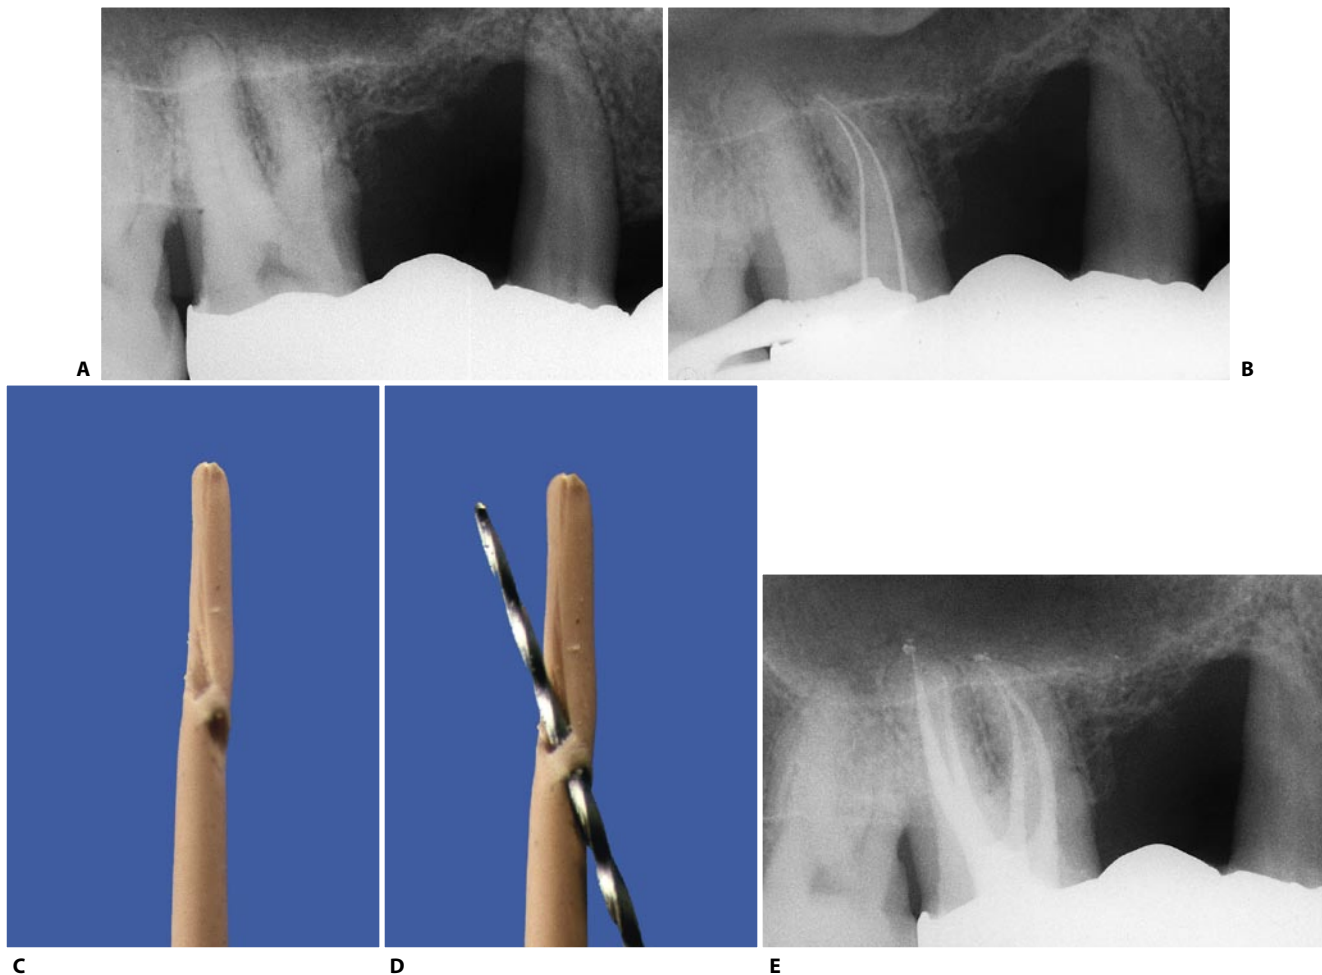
A. Preoperative radiograph of an upper right first molar. B. Two files have been introduced to radiographically document the confluence between the mesiobuccal and mesiopalatal canals. C, D. Clinical confirmation of the confluence: the instrument introduced in the mesiopalatal canal, which was yet to be prepared, has traversed the gutta-percha cone introduced in the mesiobuccal canal, which had just been prepared. E. Postoperative radiograph.
